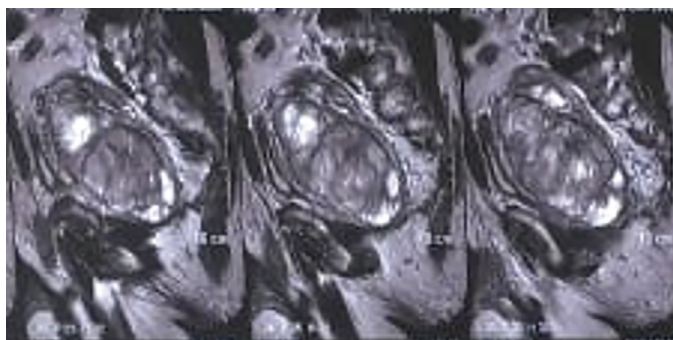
Pelvic MRI: Large heterogenous solid-cystic lesion in rectovesical space with hemorrhage and calcification
